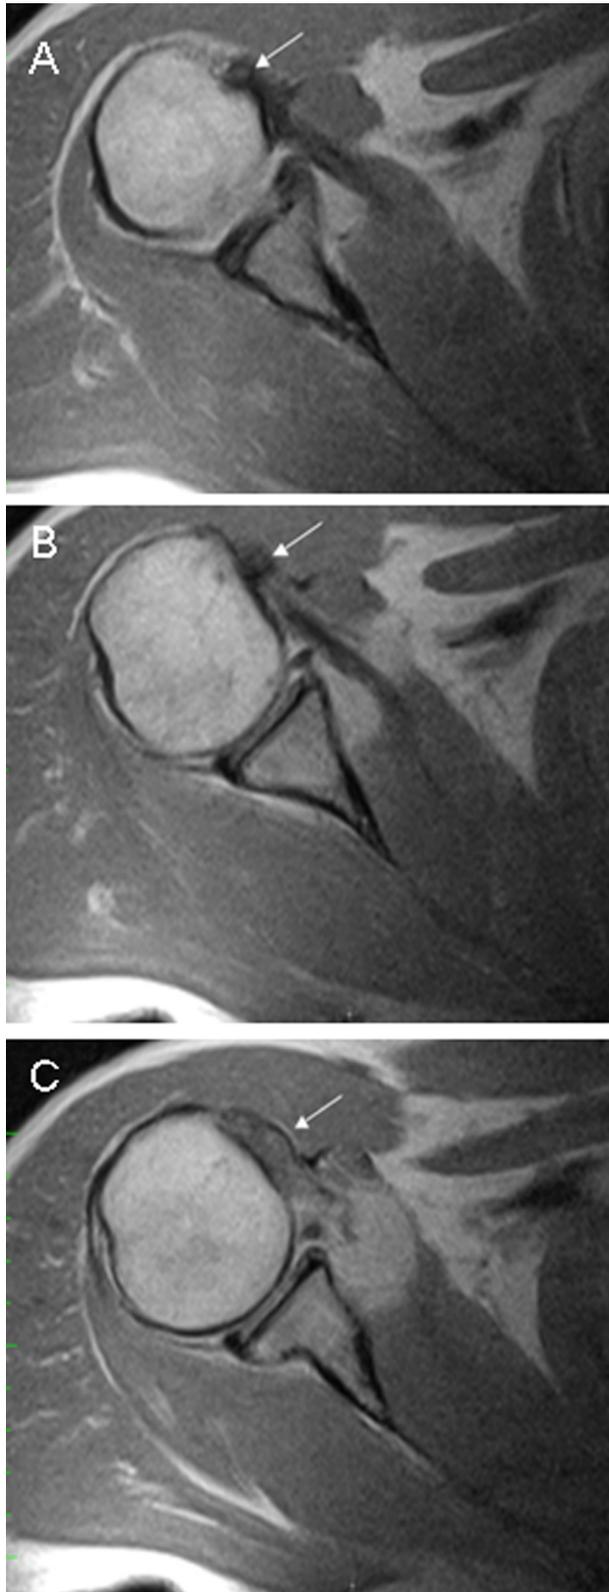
Preoperative axial MRI images of the right shoulder. *A.* The long head of the biceps brachii tendon (arrow) is clearly located in the bicipital groove. *B.* In a more proximal image, the tendon looks blurred. *C.* The LHBT is indistinguishable and merged into the superior joint capsule.
